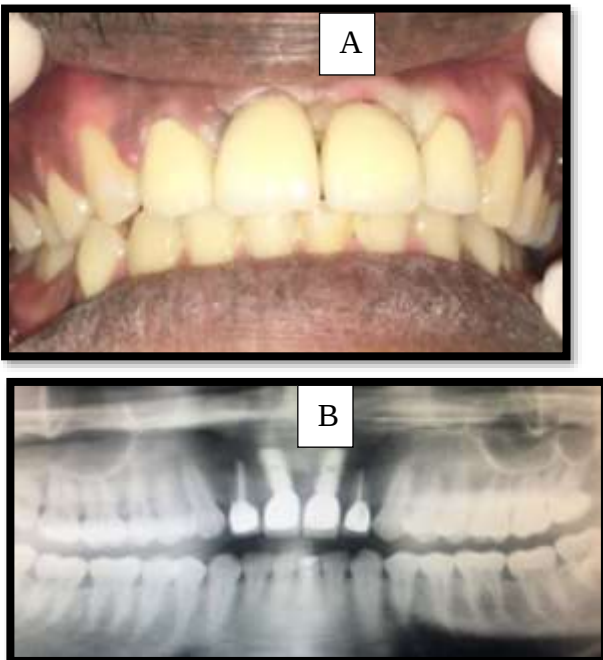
Post-operative (A) Clinical Image, (B) Radiographic
